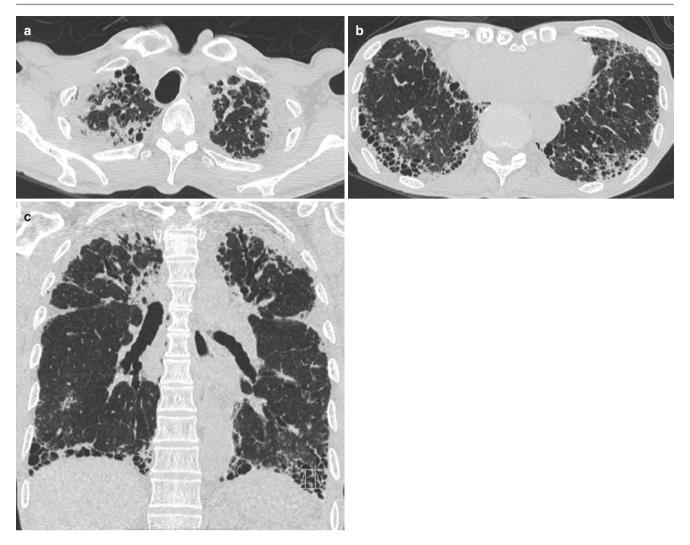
Typical UIP with PPFE. (a, b) Axial CT images show peripheral predominant reticular opacities, honeycombing with traction bronchiectasis. (c) Coronal CT image shows lower lung predominance. Upper lung fibrotic changes were presumed to be due to PPFE
